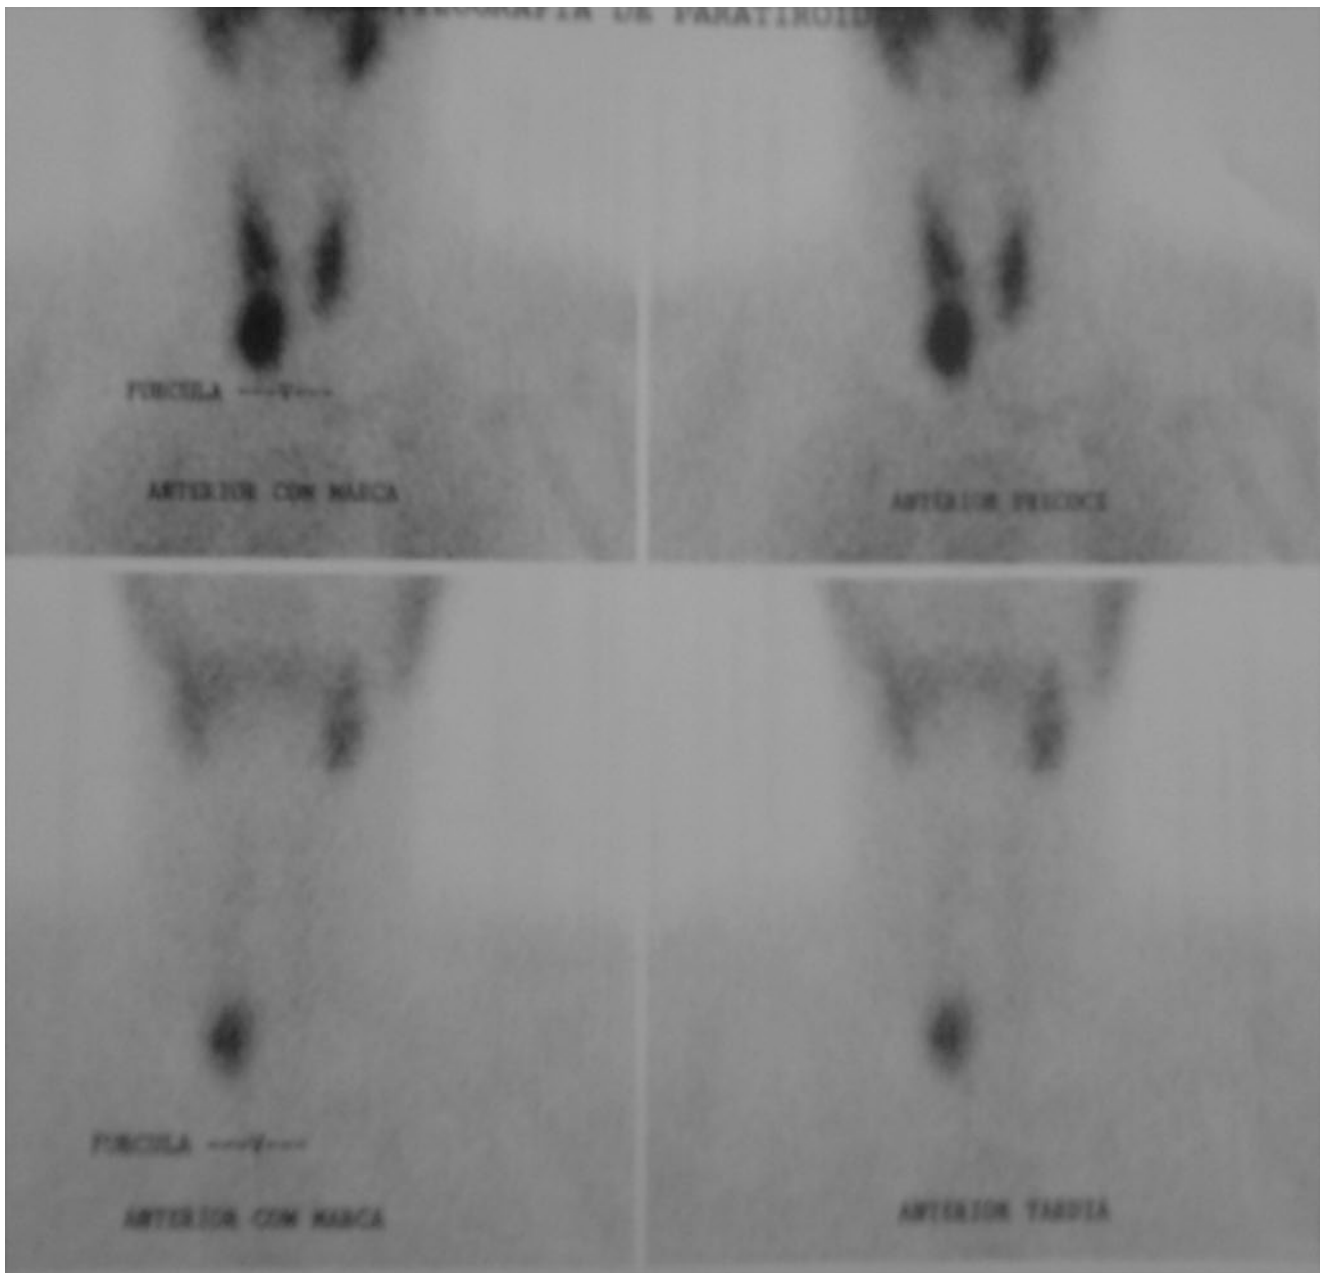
Tc-99-Sestamibi scintigraphy showing a right inferior parathyroid lesion
